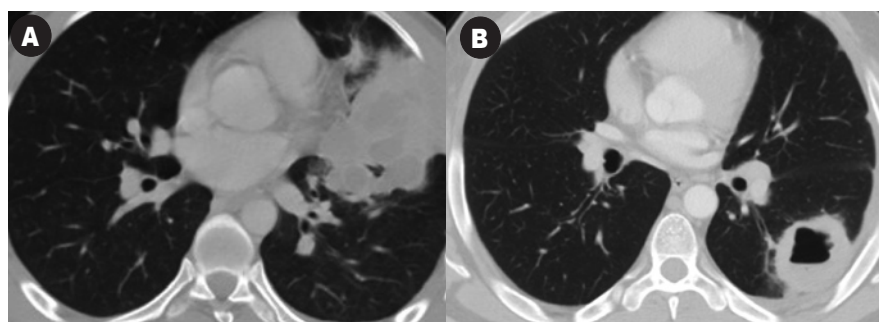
[A] Pulmonary sarcoidosis in a 48 year old man. CT demonstrates large consolidation in the left upper lobe. Note the presence of air bronchogram, which may also be seen in sarcoidosis. [B] Pulmonary cavitary sarcoidosis. A cavitary mass is demonstrated in this CT of a 50 year old man.
